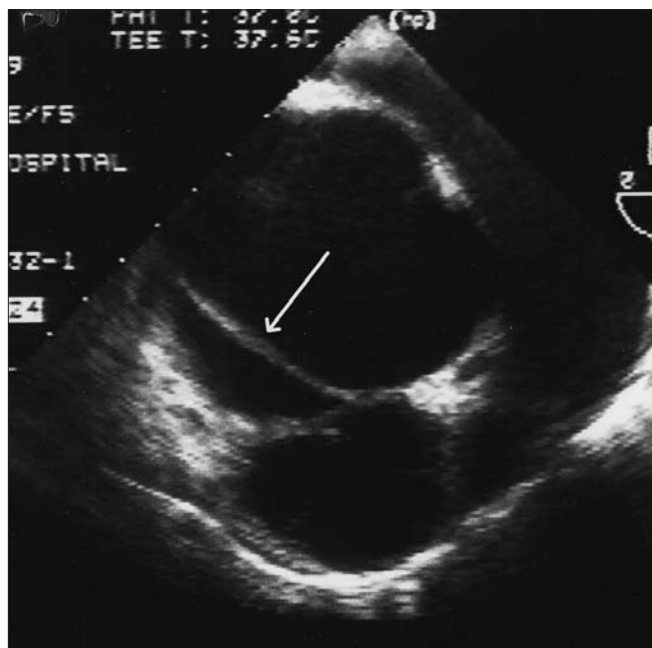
Transesophageal echocardiography demonstrating dilated aortic root and dissection flap (arrow).
